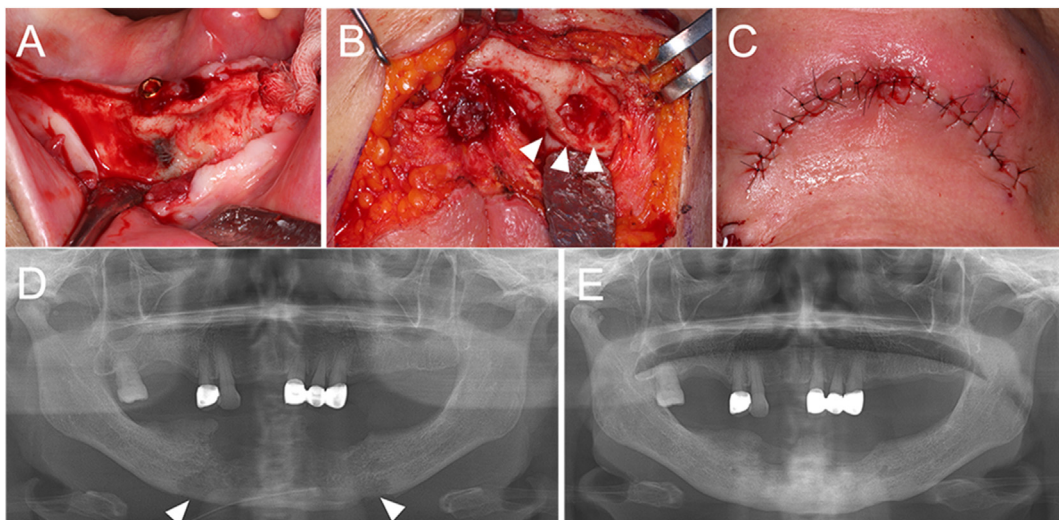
Intraoperative clinical photographs and postoperative radiographs of Case 2. (A–C) Intraoral clinical photographs showing conservative removal of the sequestrum and inflamed tissue in the area involving the inferior border of the mandible with preservation of surrounding viable bone. (D) Immediate postoperative panoramic view showing an extensive bone defect (arrowhead) extending to the inferior border. (E) Panoramic view at 9 months postoperatively.
